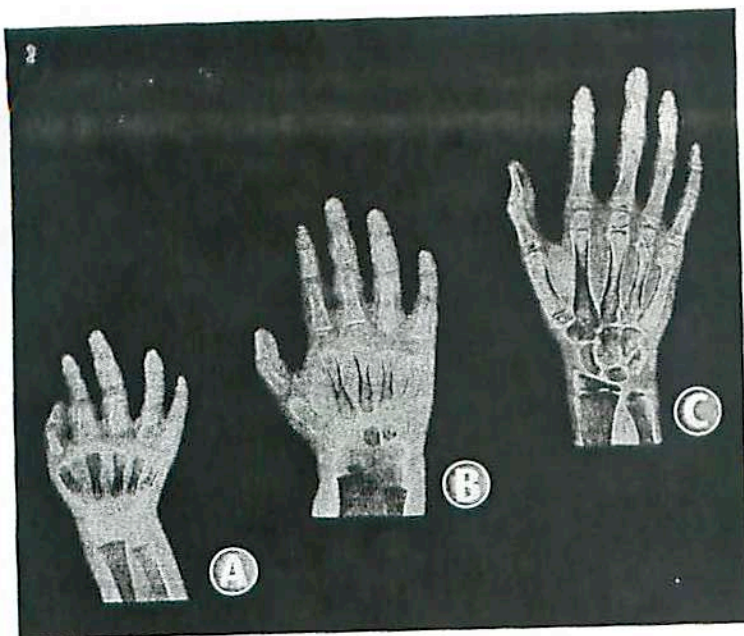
X-rays of the hands of a 1-year-old (A) and a 3-year-old (B) show that the cartilage in the wrist has not yet been replaced by bone. In the X-ray of the 13-year-old's hand (C), the replacement of cartilage by bone is almost complete.
